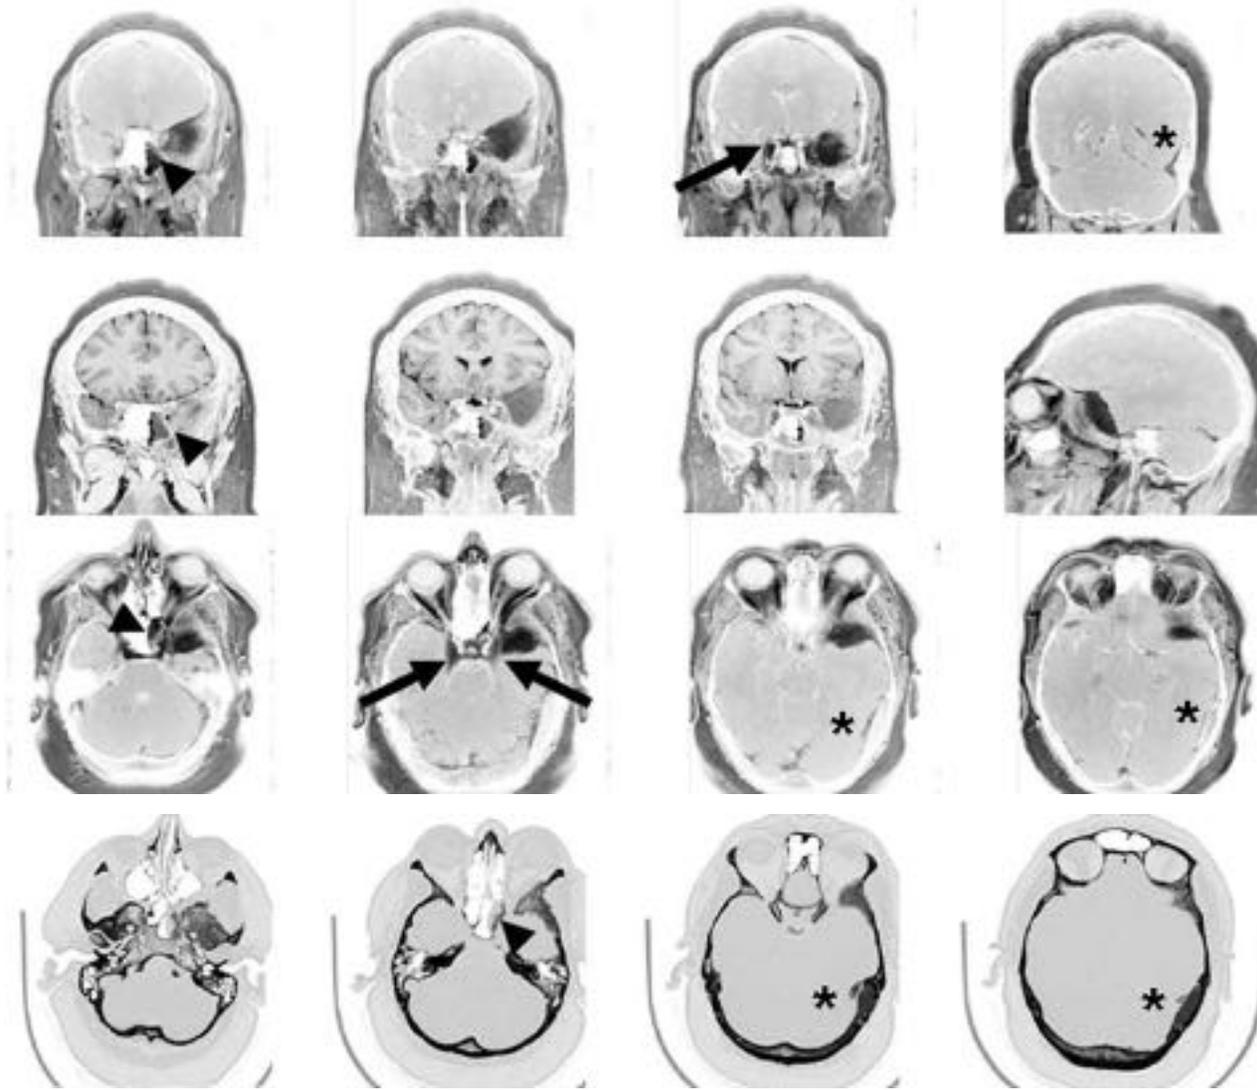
(A,B) A sphenoorbital meningioma (compare Fig. 23.4) with a sizable globular tumor component centered on the middle sphenoid wing, bilateral infiltration of the cavernous sinus (*arrows*) and growth in the paranasal sinuses (*arrowheads*). Note that there is a second en-plaque tumor in the left temporodorsal/occipital region (*). This growth pattern precludes a surgical cure. Surgical objectives in this case include removal of the intradural globular mass, and decompression of the orbit and the optic canal. (A) Triplanar T1 weighted contrast enhanced and coronal T2 weighted images delineating the globular and the en-plaque component of the tumor. (B) CT scans depict the rather extensive bony involvement. Copyright M. Simon and J. Schramm, reproduced with permission.
